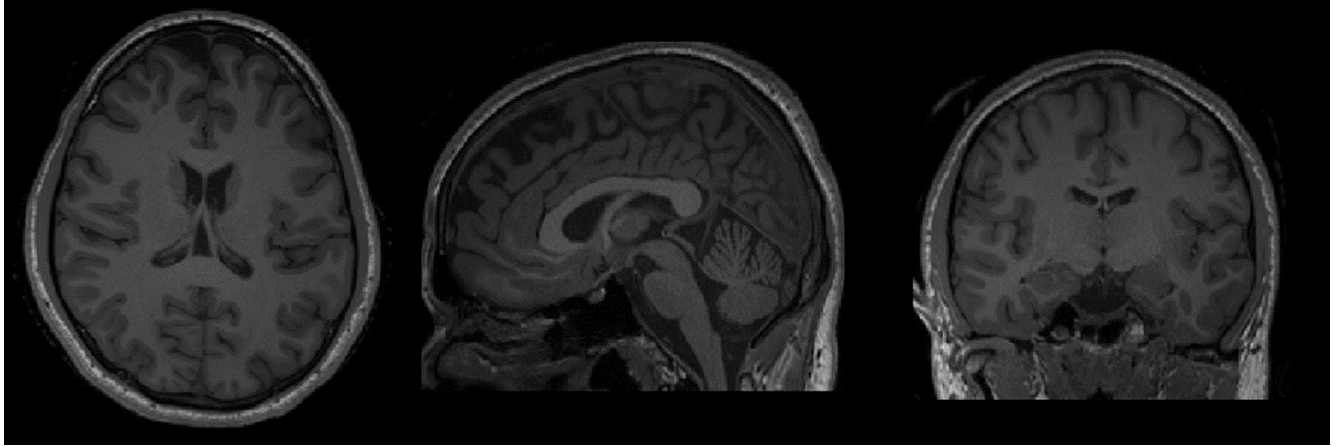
T_1 -weighted MRI brain scan for a single subject, including the transverse plane (left), sagittal plane (center), and coronal plane (right).
